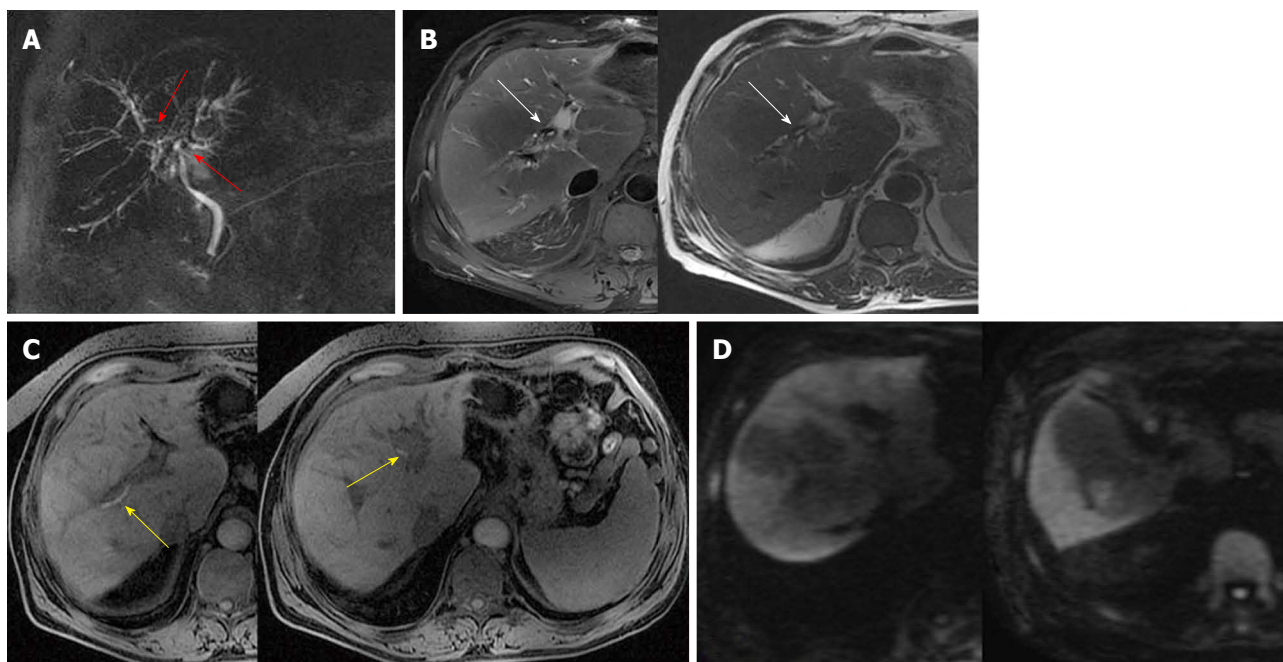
Non-anastomotic biliary stricture: Advanced ischemic type biliary lesion. A: Single-shot thick-slab magnetic resonance cholangiogram demonstrates a stenosis of the hepatic bifurcation and hepatic ducts (red arrows) with an irregular dilation of the intrahepatic biliary system; B, C: Axial T2- and axial T1-weighted images well exhibit the presence of circumferential wall thickening (white arrows) at the level of hepatic bifurcation and endoluminal casts (yellow arrows); D: On diffusion-weighted imaging the liver parenchyma appears inhomogeneous with multiples areas of persistent high signal intensity in highest *b*-value acquisitions.
